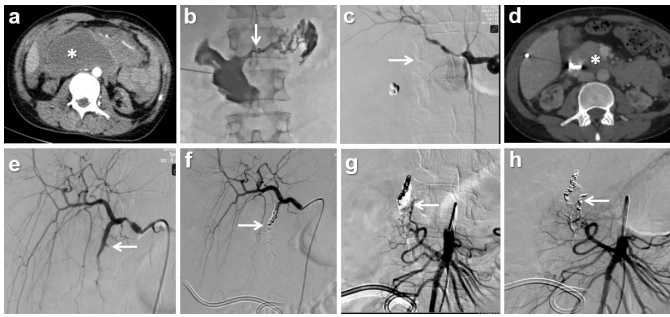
Digital subtraction angiography (DSA), fluoroscopy, and computed tomography (CT) images of a 25-year-old female patient with chronic renal failure and massive upper GIS bleeding. Axial CT image (a) shows a periduodenal hematoma (asterisk), fluoroscopy image (b) shows a perforated peptic ulcer (arrow), DSA image (c) shows that the gastroduodenal artery (GDA) is not filled due to vasospasm (arrow), and CT image (d) shows that the hematoma healed after percutaneous drainage and embolization. The images of the second DSA procedure (e and f) demonstrate the pseudoaneurysm (arrow) originating from the GDA and embolization with coil + glue. Images (g) and (h) show the coil embolization of the inferior pancreaticoduodenal artery originating from the superior mesenteric artery.
